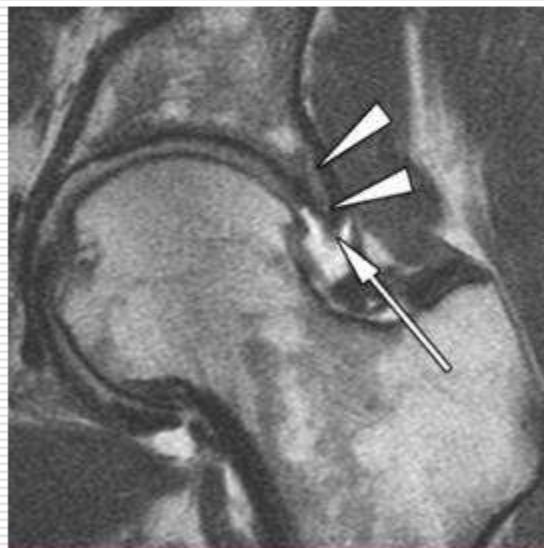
Coronal MR images obtained with an intermediate-weighted fast spin-echo sequence with fat saturation (2500/42) (left) and a T1-weighted spin-echo sequence (524/14) (right) show ossification of the acetabular labrum in a patient with pincer FAI. Bone marrow signal (arrowheads) extends into the substance of the acetabular labrum (arrow).
